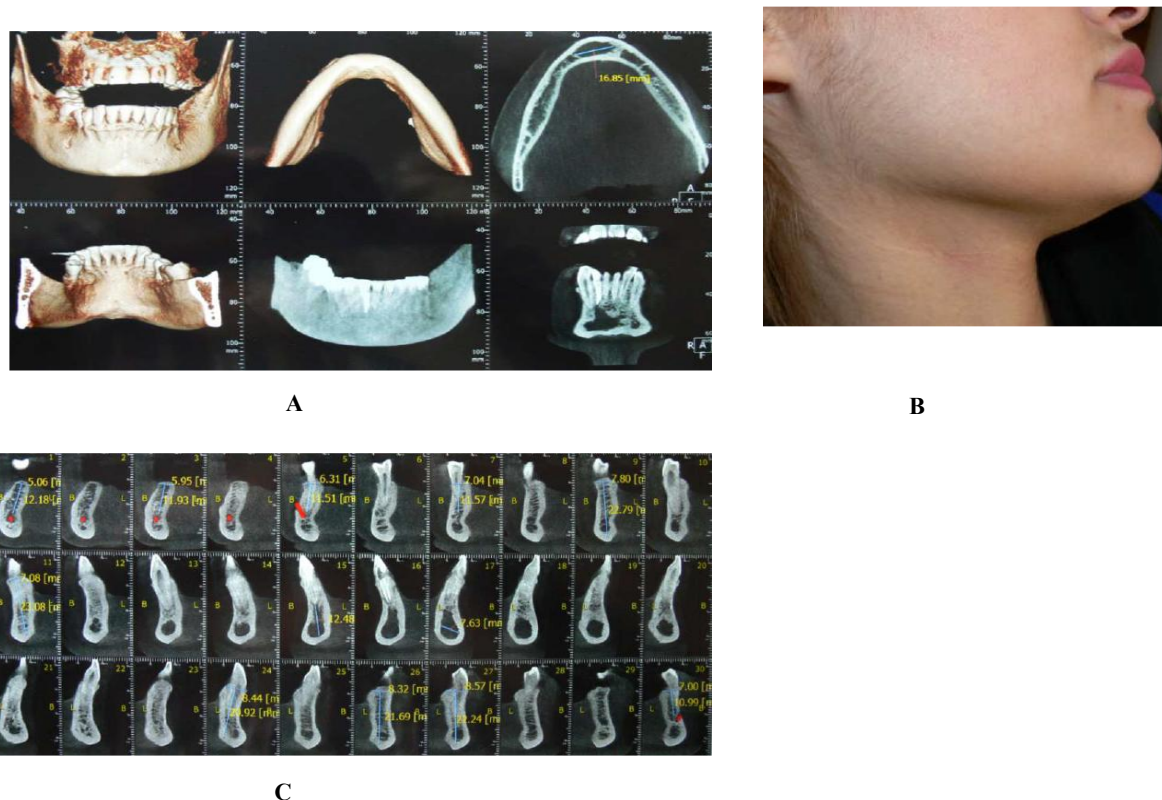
(A, B) CBCT images. (C)Extra-oral image. Year 2015
